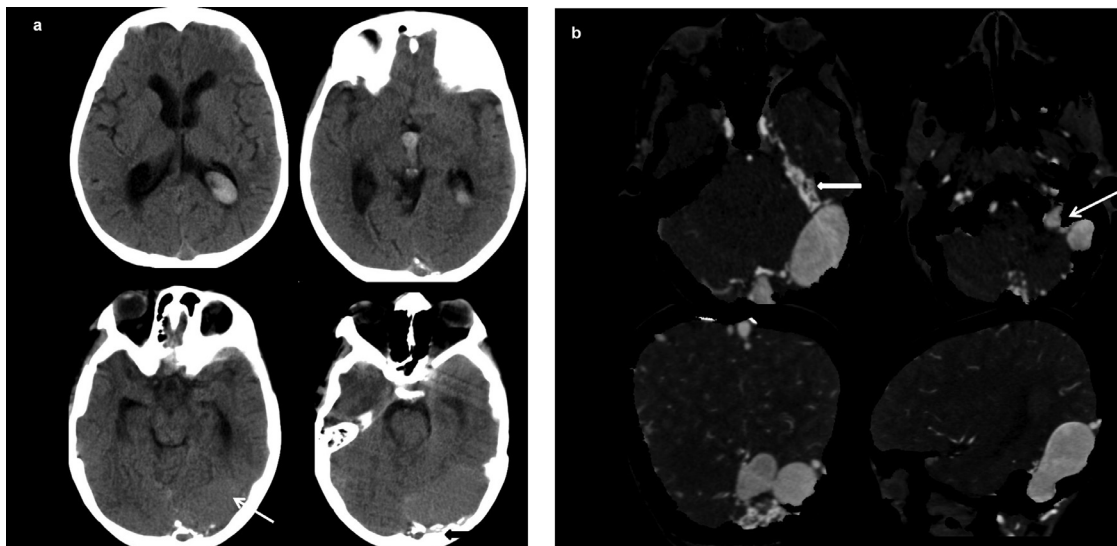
Contrast-enhanced CT scan head of the patient at 7 years of age. (a) Axial NCCT head images show a lobulated hyperdense (68 HU) extra-axial lesion along the left occipital convexity (white arrow) with few calcific densities within (black arrow) and scalloping of the inner table of overlying calvarium. Intraventricular hemorrhage was noted. (b) Axial, coronal, and sagittal CT angiography images show intense contrast enhancement of the lesion which measured 2.5 × 4.2 × 6.5 cm. A thin curvilinear area with calcifications on NCCT did not show enhancement s/o chronic partial venous sinus thrombosis. The left internal jugular vein was dilated (thin arrow). Feeders were seen along the left tentorium cerebelli (thick arrow). There was atrophy of the left occipital and left cerebellar hemisphere.
